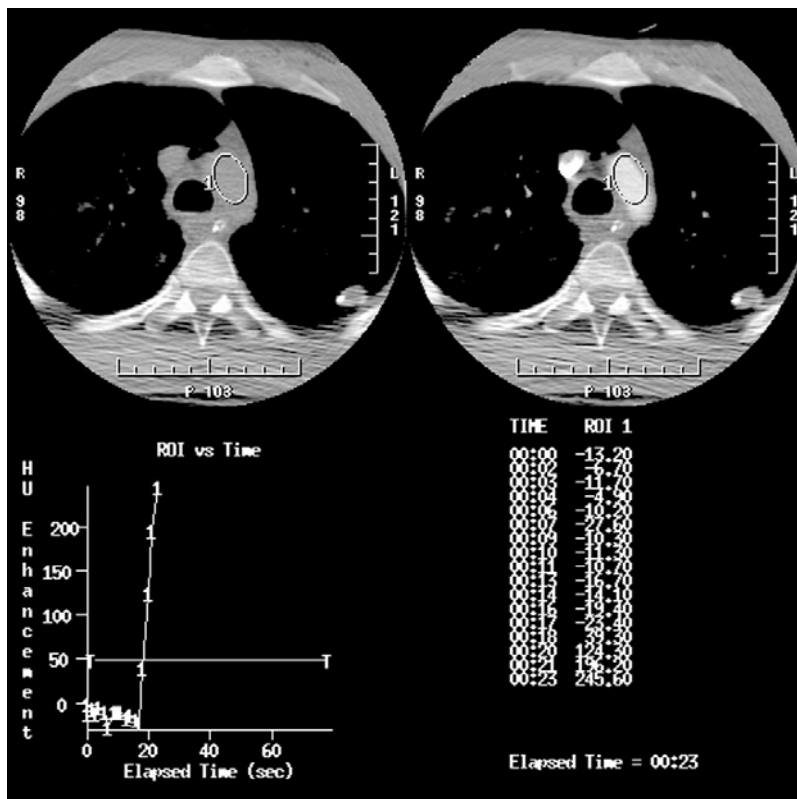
Automatic triggering for CTA. The cursor is placed in the aorta, and sequential images are obtained during dynamic contrast injection. Scan commences when contrast density in Hounsfield units (HU) reaches a preset value of 50–100 or when the technologist visually sees sufficient opacity in the arteries. Note contrast enhancement versus time curve
